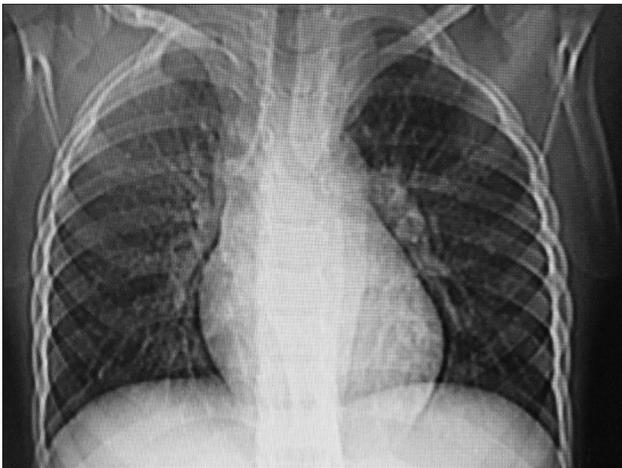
Plain chest radiography shows increased lucency over the left side due to the absence of chest muscle
